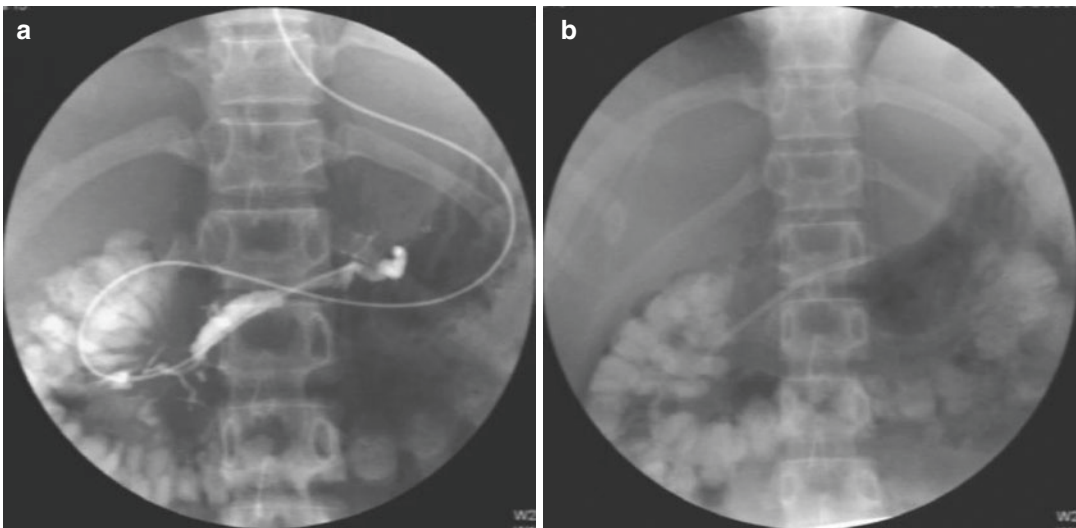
(a) X-ray demonstrated the stricture in the pancreatic head, and irregular dilatation in the pancreatic body and tail. (b) X-ray demonstrated that the stent had successfully passed the stricture of the accessory pancreatic duct
